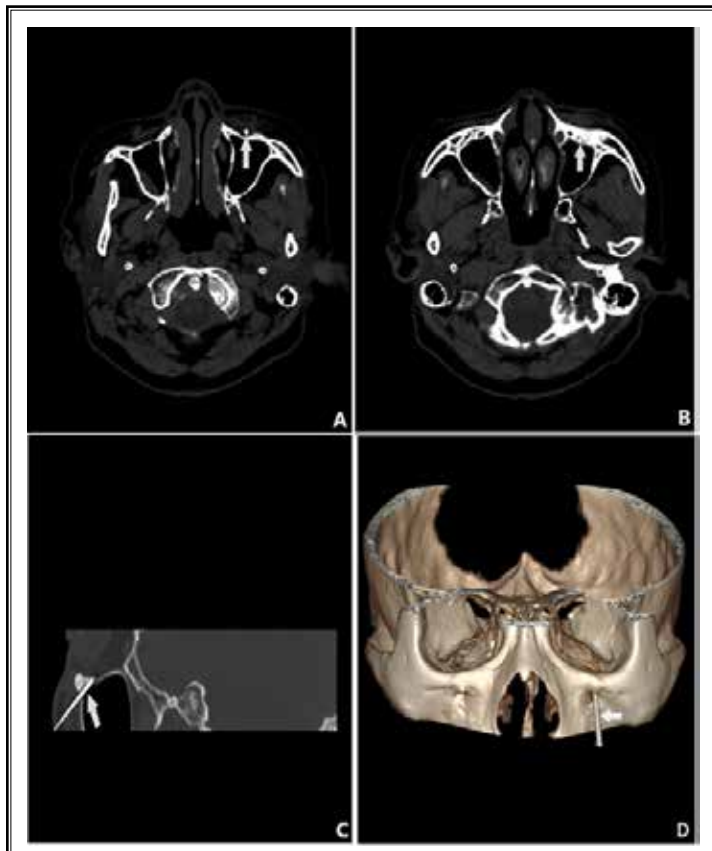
Operative puncture of the infraorbital foramen. (A) Axial CT scan of maxillary sinus showing the tip of the trocar entering the ipsilateral infraorbital notch. (B) Axial CT scan of maxillary sinus showing the tip of the trocar entering the ipsilateral infraorbital foramen. (C) Sagittal CT scan of maxillary sinus showing the needle entering the ipsilateral infraorbital foramen. (D) 3-D reconstruction of spiral CT shows the needle entering the ipsilateral infraorbital foramen.
